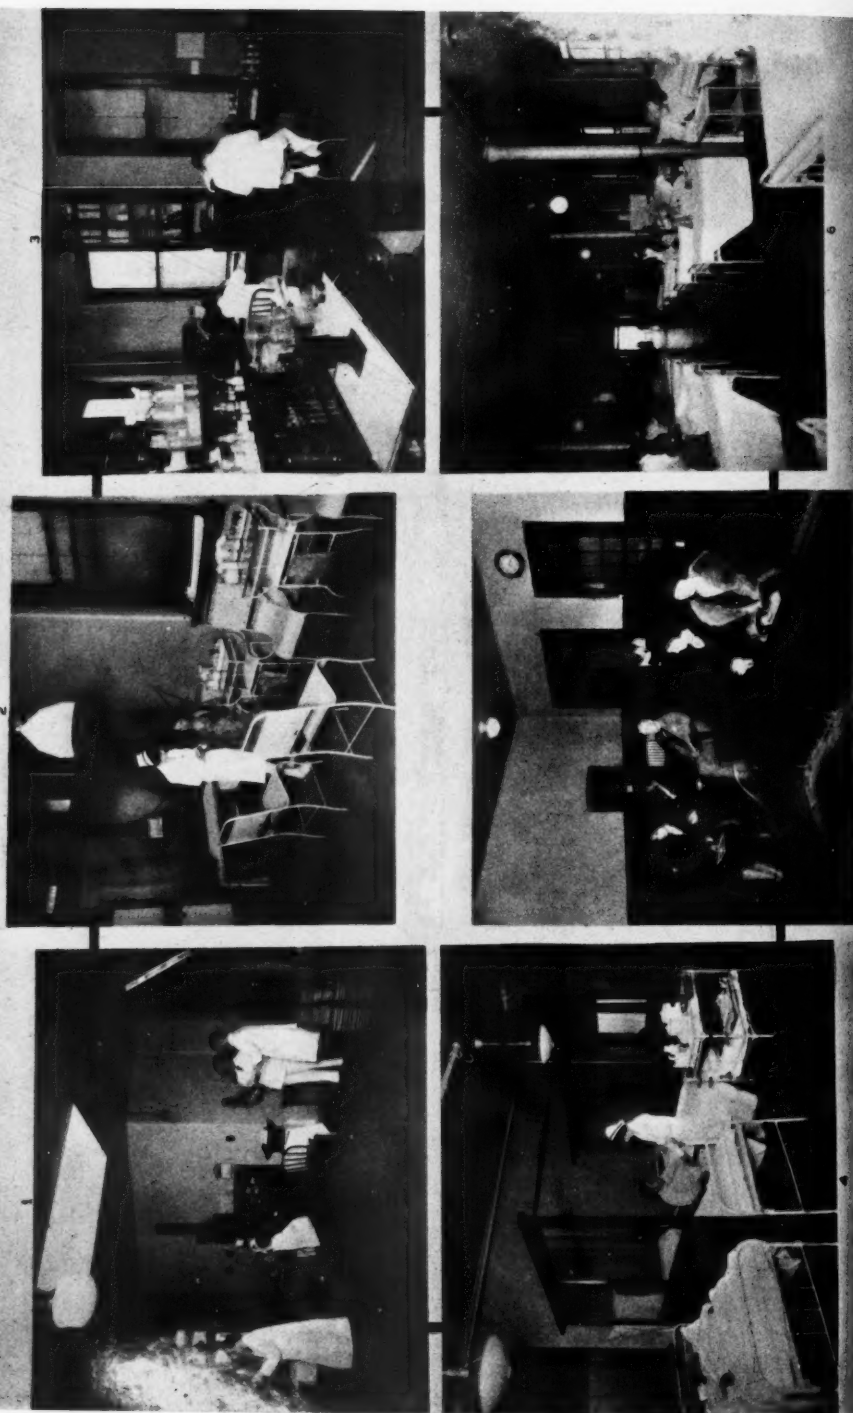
(1) X-ray Therapy Department. (2) Clinic Examining Room. (3) Cubicle Ward, Cancer Clinic. (5) Waiting Room. Cancer Clinic. (6) Male Cancer Ward, Island Hospital.
